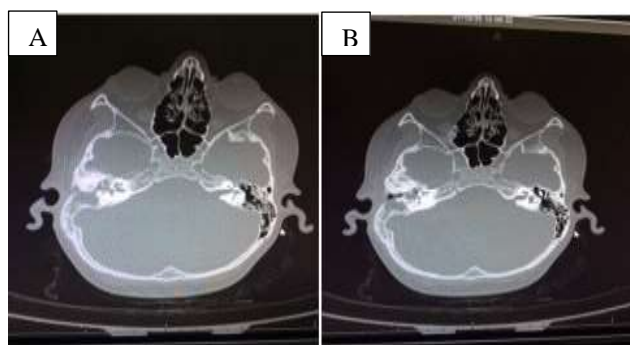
A and B are CT scans of the temporal bone showed soft tissue shadow filling the right mastoid air, no ossicles could be identified.
